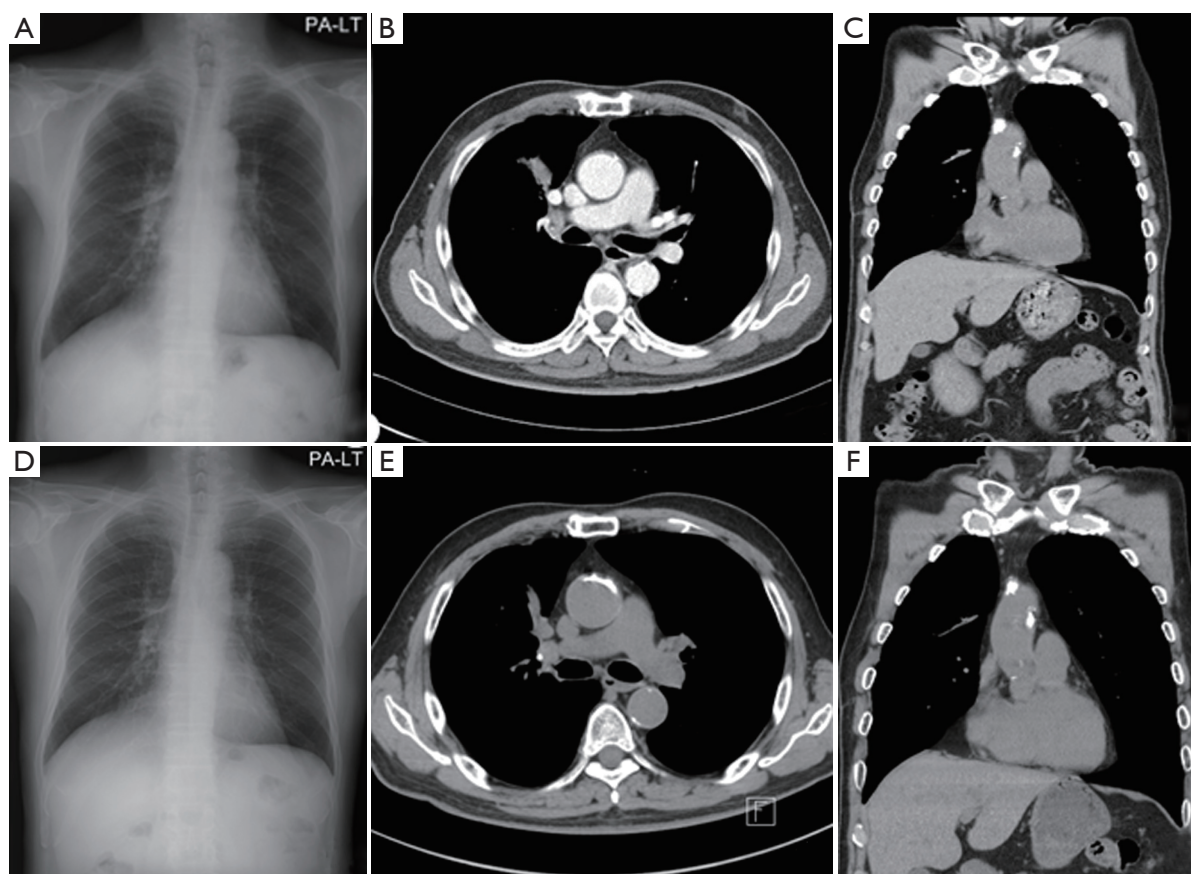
(A-C) Chest X-ray and computed tomography (CT) which were taken on April 2013; (D-F) chest X-ray and CT on August 2013.
